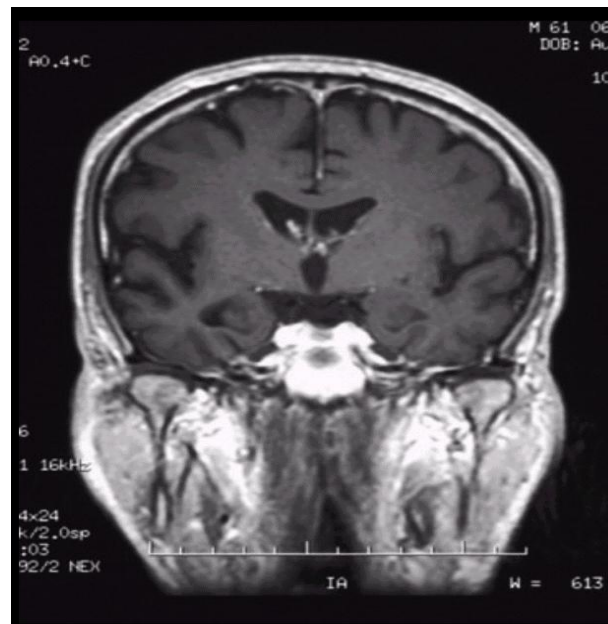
Coronal, T1-weighted magnetic resonance imaging (MRI) scan in a patient with moderate Alzheimer disease. Brain image reveals hippocampal atrophy, especially on the right side.
